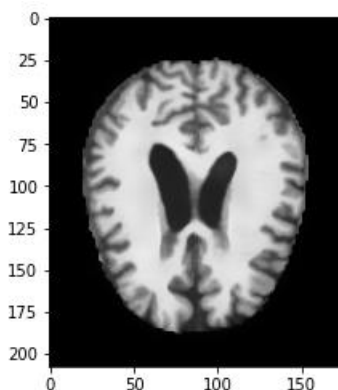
Input MRI Image it will predicted by Moderate Demented
